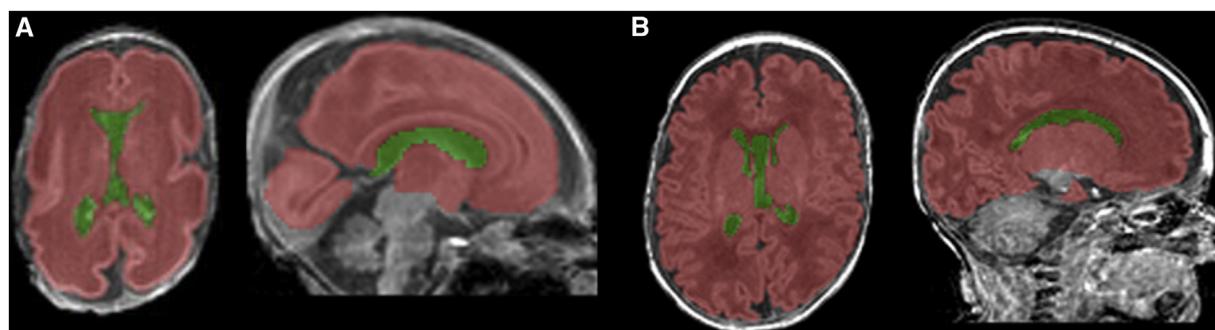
Segmentation of supratentorial ventricular volume (VV) and total cerebral volume (TCV) on T1-weighted MRI of a single neonate A, early after birth and B, at TEA.
